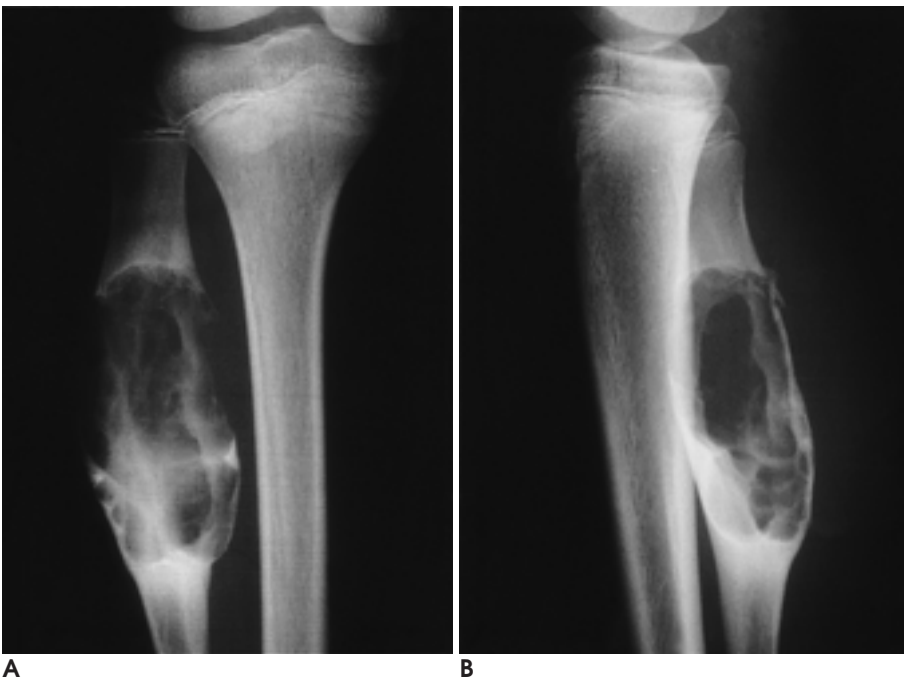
Anteroposterior (A) and lateral (B) radiographs of the right leg show a large expanded, lobulated osteolytic mass in the metadiaphysis of the fibula. This mass has sclerotic rim and multiple septa.
